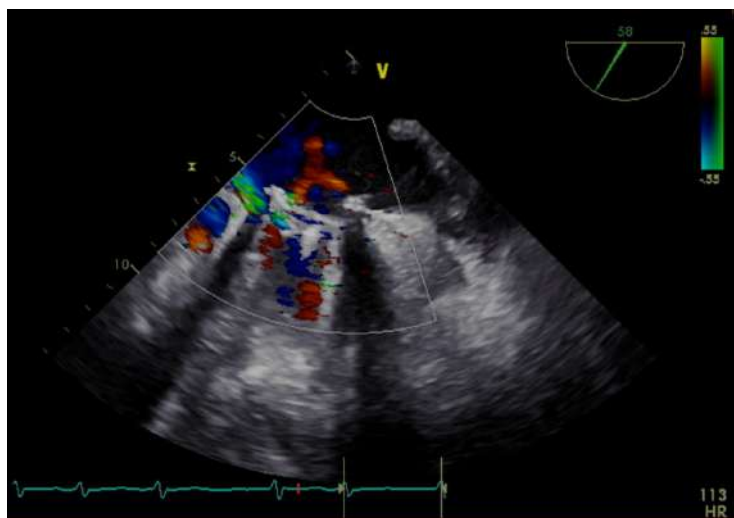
Commisural view of TEE with colour Doppler at systolic phase, showing the mechanical MV
